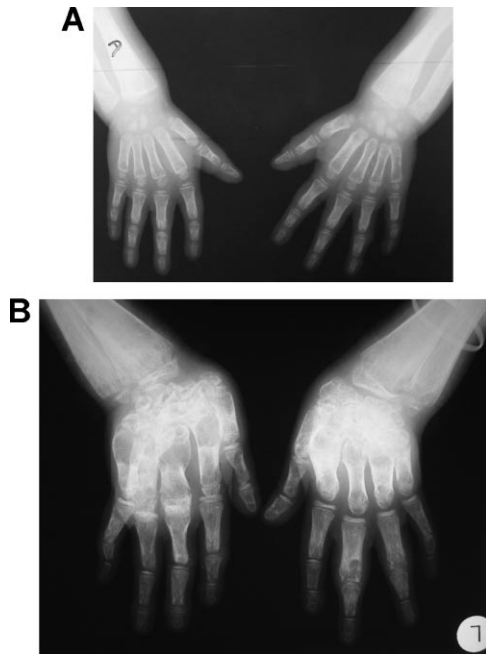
Hand radiograph at 3 (A) and 11 years (B). Note ulnar deviation of the hand, progressive enlargement of distal metaphyses and progressive cystic changes in metacarpals. Cortical density becomes reduced.
